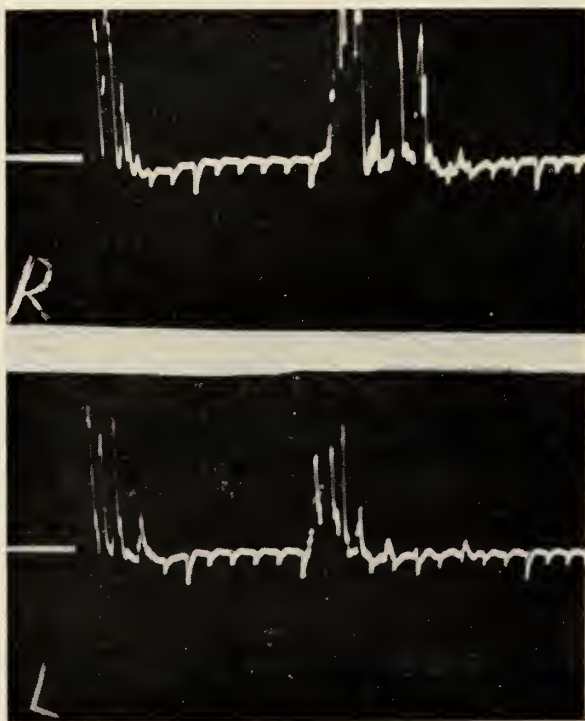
(Case 3.) A-mode sonograms of both eyes. No evidence of retinal detachment in right eye. Shallow anterior chamber of left eye.
